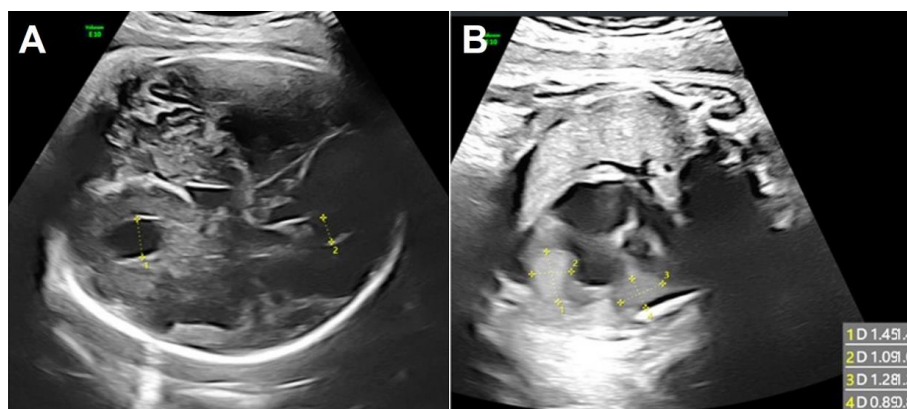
Prenatal ultrasound at intrauterine period 37 weeks and 0 days. (A) Brain sonography showed left side ventriculomegaly. (B) Echocardiography revealed masses sized 15×11 mm (right ventricle) and 13×9 mm (left ventricle). Written informed consent was obtained for publication of this case report and accompanying images.
